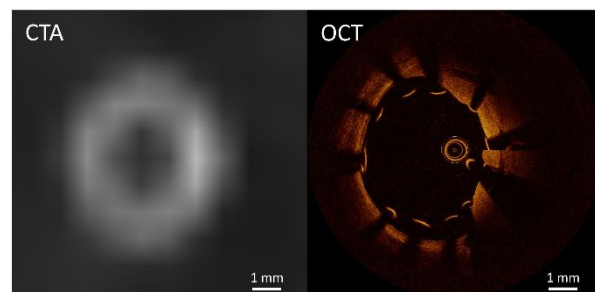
CTA and OCT scan of the same position. OCT shows stent strut malapposition, not observed with CTA.
